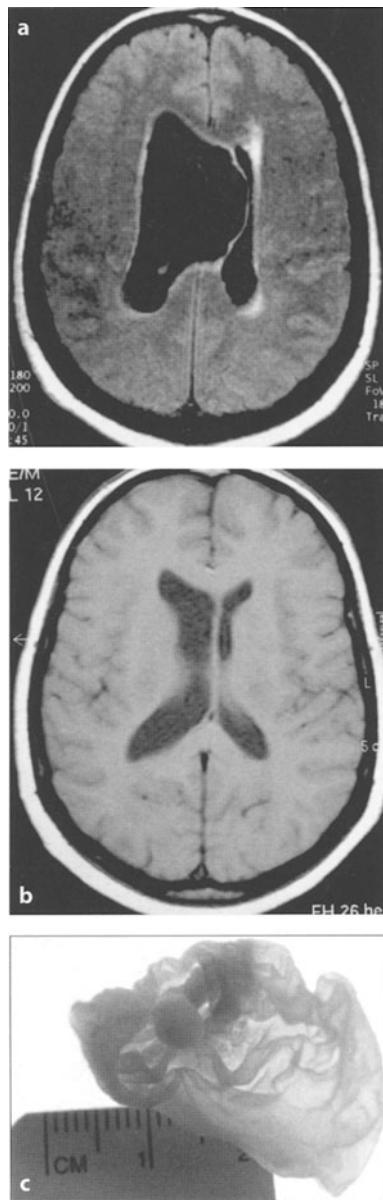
a FLAIR MRI revealing a giant intraventricular cysticercus. b Postoperative T1-weighted MRI. c Cysticercus cellulosae endoscopically extracted
